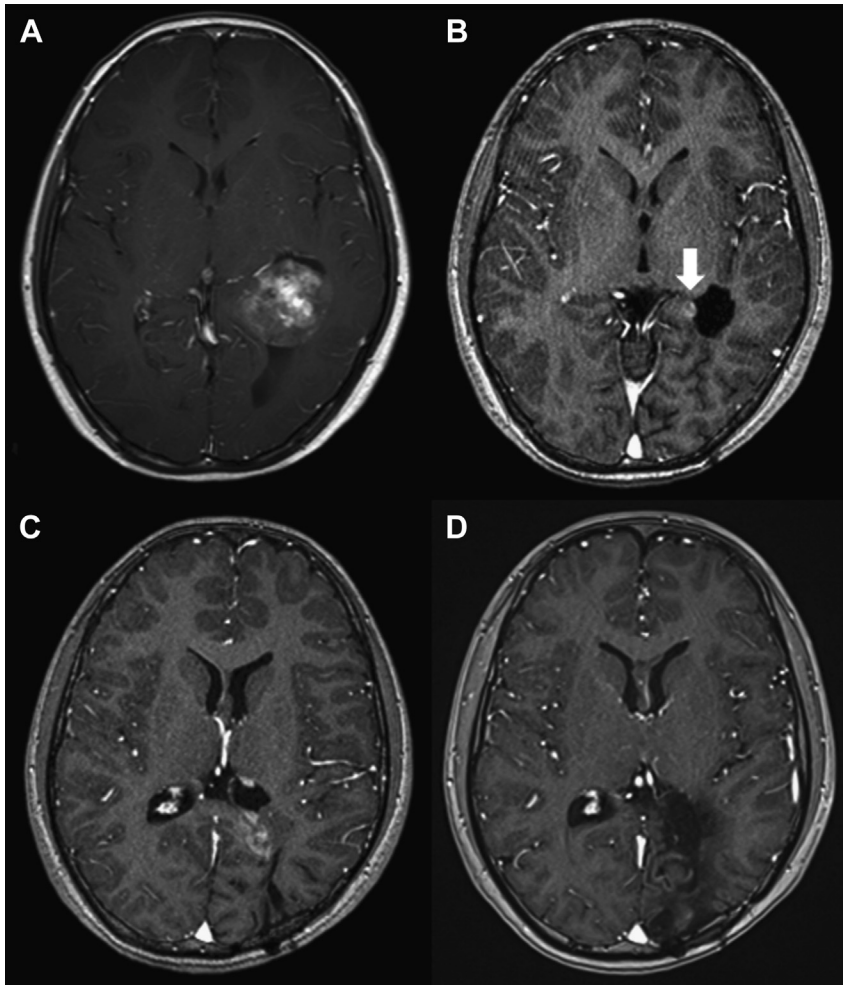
MR images from a 10-year-old boy. (A) Initial preoperative MRI shows a well-demarcated mass in the left trigone. (B) The mass was completely removed in the second operation. A small enhancing nodule (*arrow*) developed after 17 months and the patient underwent radiosurgery for the lesion. (C) The lesion increased in size and extent 1 year after the radiosurgery. He received a third operation and proton beam therapy. (D) Two years after a third operation, there is no recurrence of tumor.
